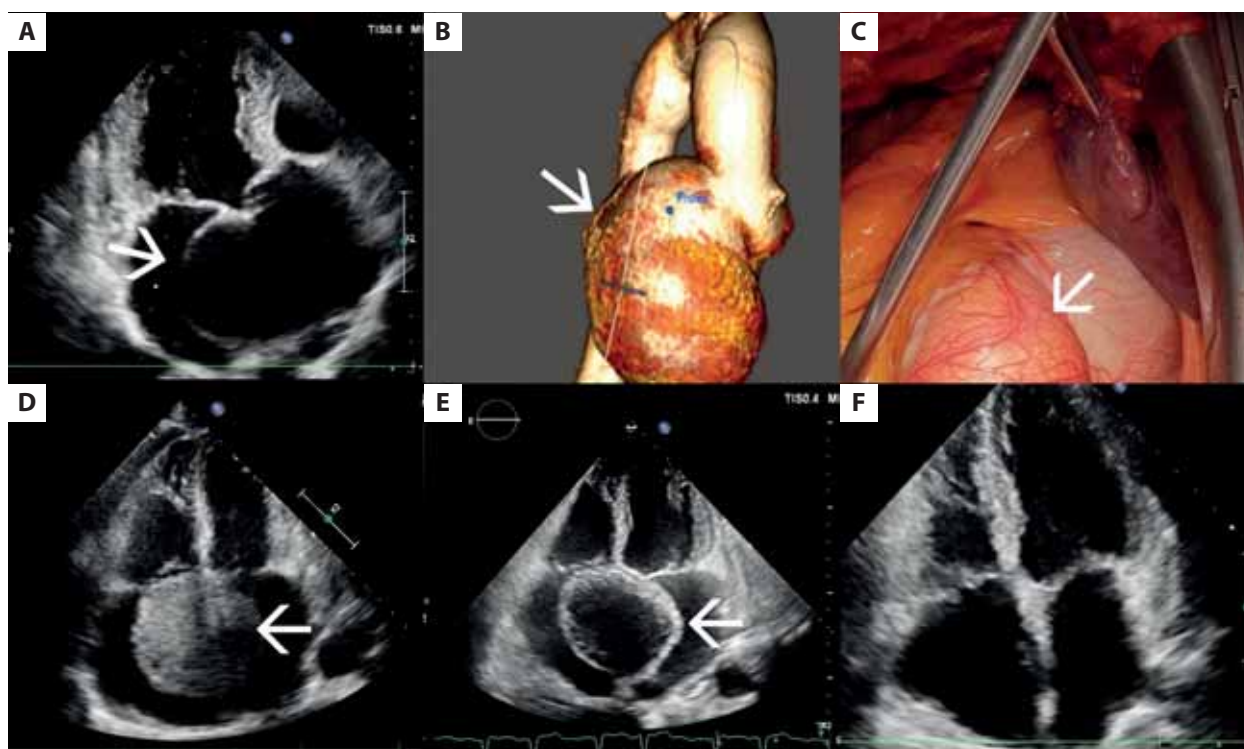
A. Transthoracic echocardiogram (TTE) before the procedure, modified 5-chamber view (arrow indicates the sinus of Valsalva aneurysm). B. Cardiac computed tomography angiography: 3-dimensional reconstruction (arrow indicates the sinus of Valsalva aneurysm). C. Periprocedural image. D. TTE; 4-chamber view (arrow indicates an intramural hematoma). E. TTE, 4-chamber view 7 days after the procedure, partial resolution of the hematoma (arrow indicates an intramural hematoma). F. TTE, 4-chamber view 1 year after the procedure, resolution of the hematoma
